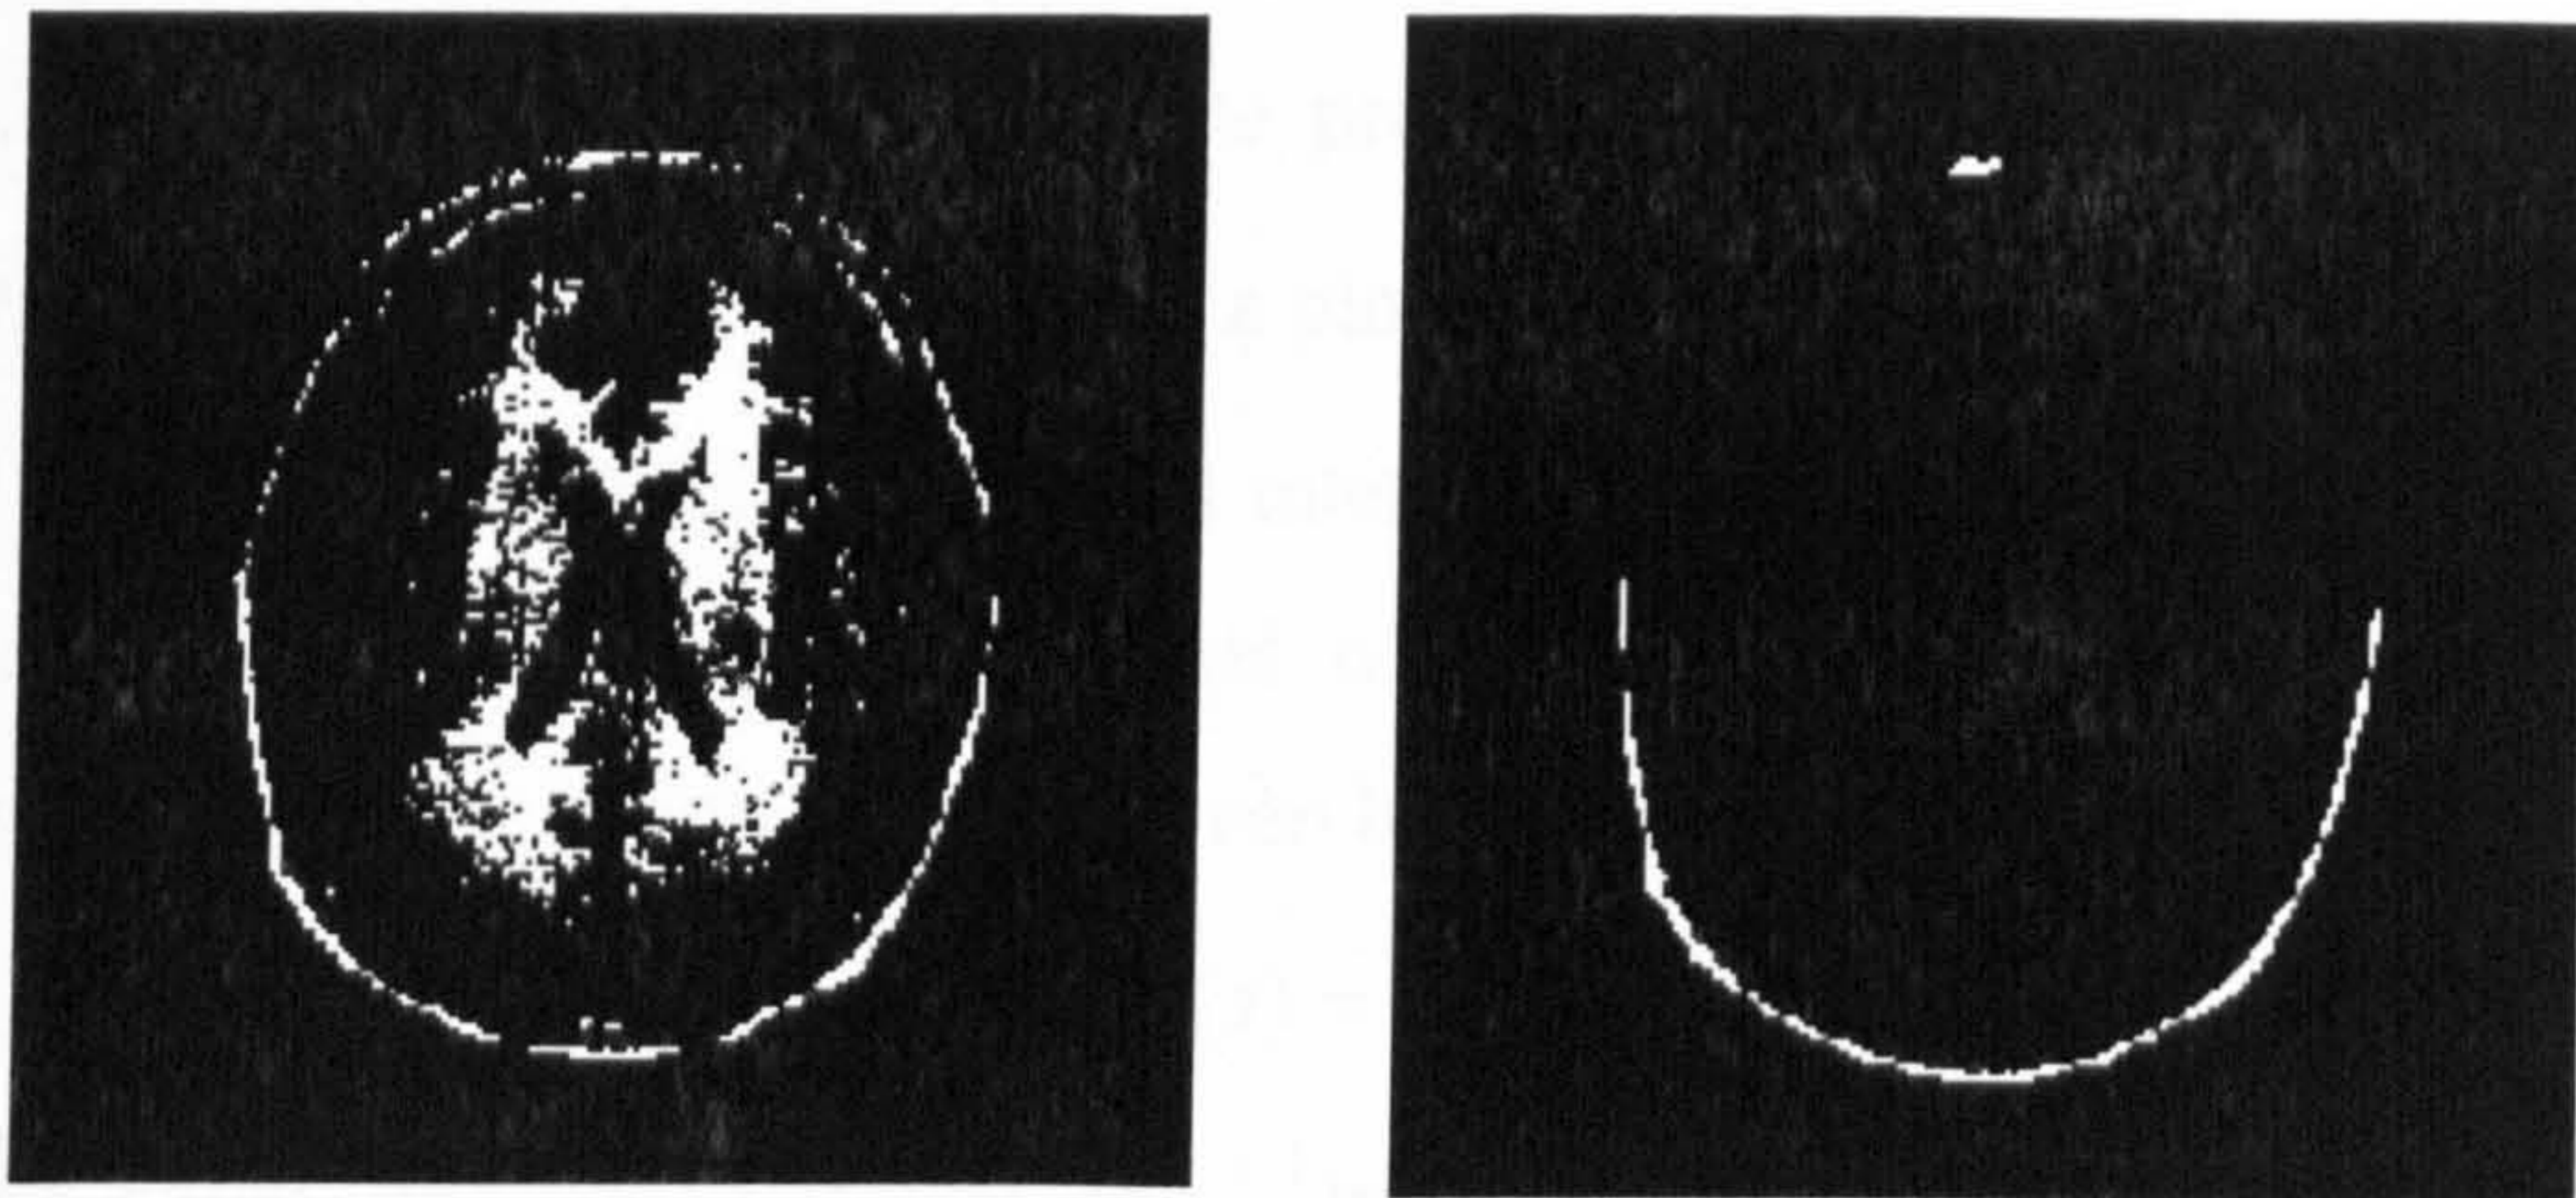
Removal by morphological processing.(a) original T_1 -weighted MR image
